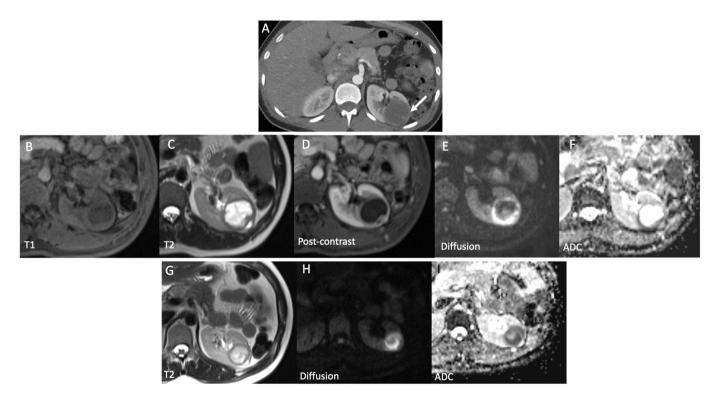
Renal tuberculosis. A) Contrast-enhanced CT shows a hypo-enhancing cystic lesion in the left kidney (arrow). MRI demonstrates a well-defined, septate cystic lesion which is B) T1 hypointense and C) T2 hyperintense in the interpolar region. The lesion also has a thick T2 hypointense wall which shows D) post-contrast enhancement and E and F) diffusion restriction. G, H and I) MRI 3-months post anti-TB treatment shows a reduction in size of the lesion along with presence of caseating material within the lesion as apparent by increased diffusion restriction within the fluid content.
